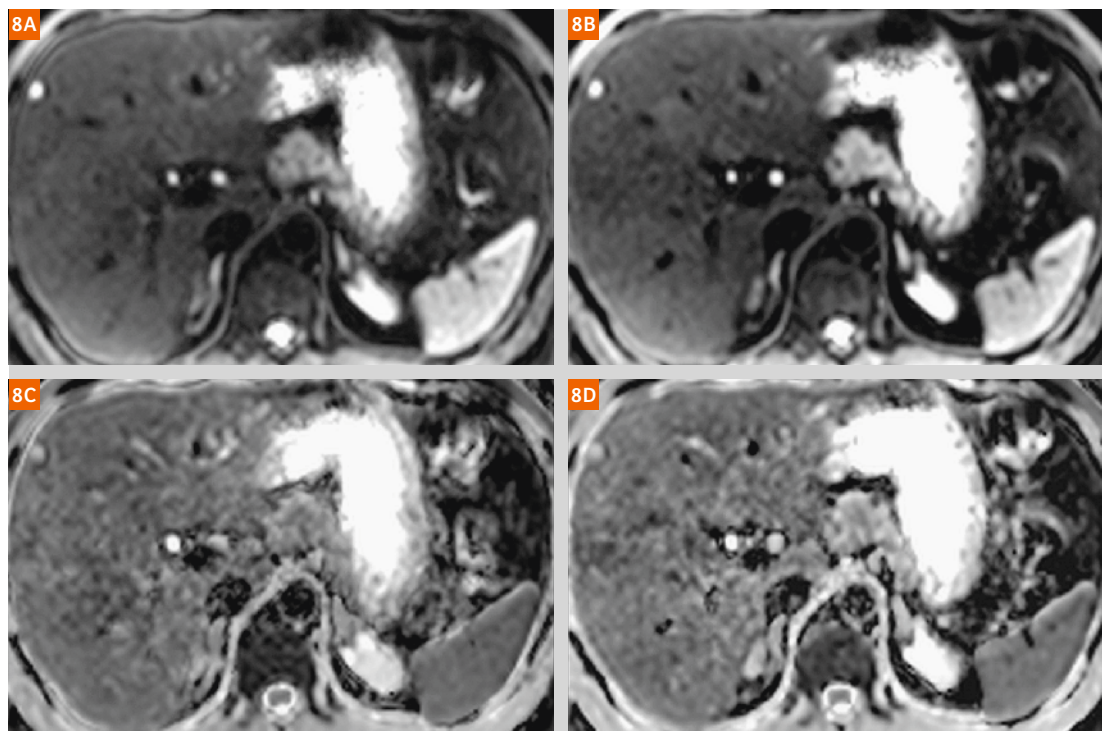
Small hepatic cysts. Liver DWI, (8A, C) no SMS in comparison to (8B, D) SMS 2, b-value 800 s/mm² top, ADC bottom. Scan times were 4:14 vs 2:31 min, with the same anatomic coverage (number of slices) for both scans and complete liver coverage (using a 4 mm slice thickness).
